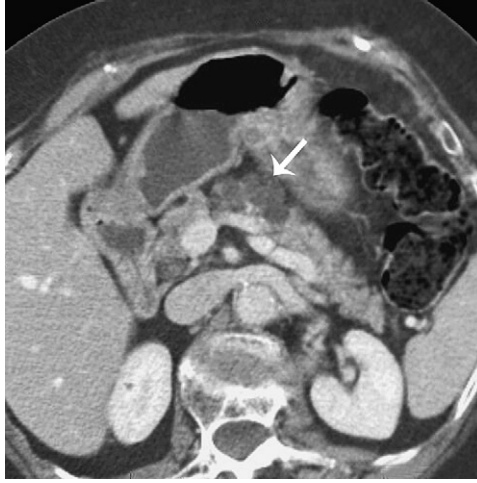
Side branch IPMN. Axial CT sections show multiple cysts in the head and neck portions of the pancreas (*arrow*) that communicate with the pancreatic duct, which is of normal caliber in the body-tail segment.
